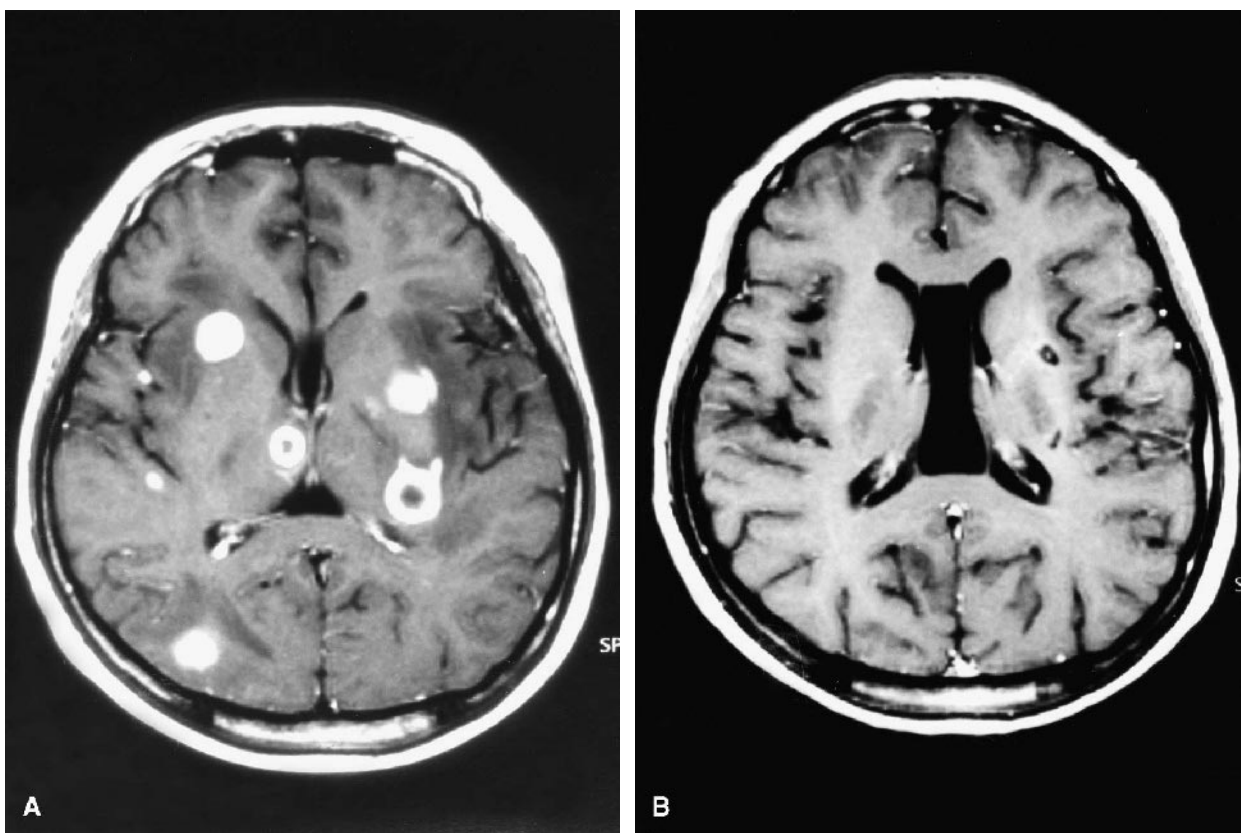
A, Axial MRI of the brain enhanced with gadolinium shows ring-enhancing lesions in both basal ganglia. B, Axial MRI of the brain enhanced with gadolinium shows small multiple lesions with ring enhancement in the left basal ganglia 6 months after the peripheral stem cell transplantation.
